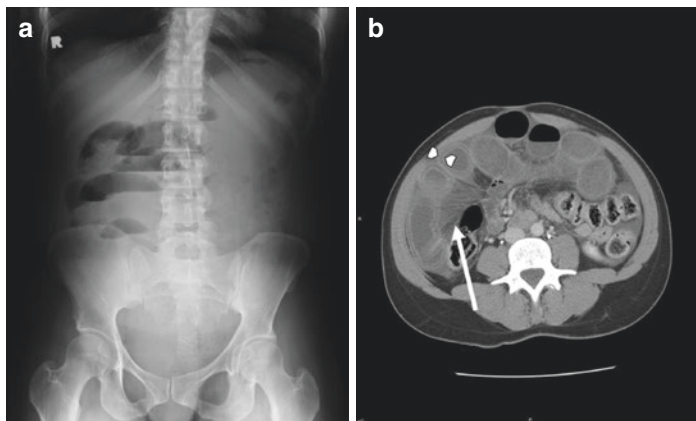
Closed loop small bowel obstruction. (a) Upright plain radiograph demonstrates air fluid levels with a paucity of small bowel gas. (b) CT scan reveals evidence of possible ischemia. White arrow indicates mesenteric fluid and stranding. Bowel wall thickening, edema, and enhancement demonstrated by white carrots
